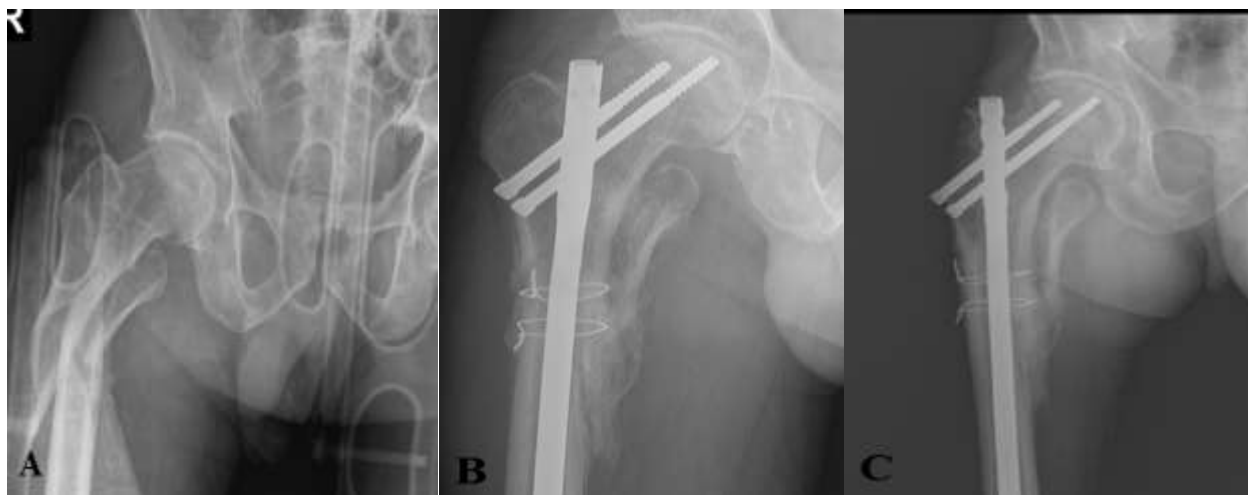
(A)- Comminuted subtrochanteric fracture, AP view; (B)- 3 months postoperative radiograph showing osteosynthesis with straight nail and cerclage wires- AP view; (C) - 3 months postoperative radiograph showing osteosynthesis with straight nail and cerclage wires- oblique view
